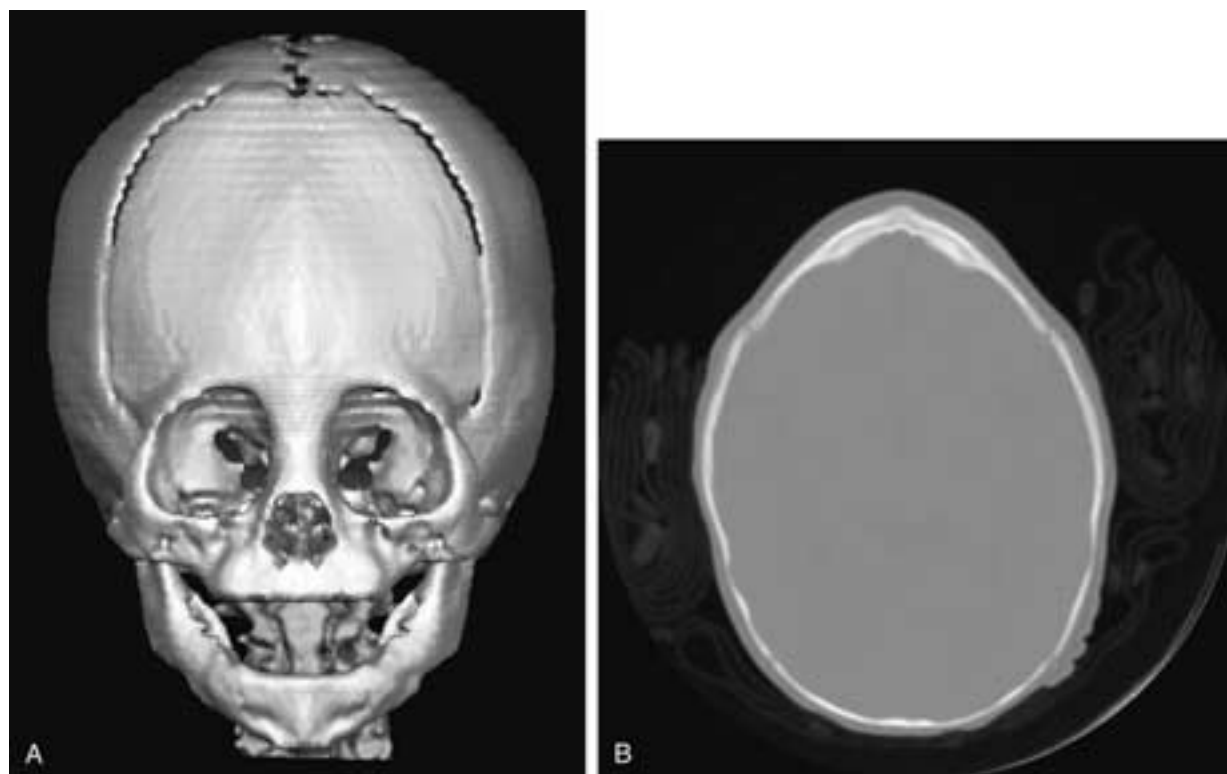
Trigonocephaly in a 3-month-old girl. A, Three-dimensional CT of the facial skeleton. B, Axial bone CT through the metopic suture. Premature closure of the metopic suture leads to hypotelorism, upward medial pointing of the orbital contours (“quizzical orbits”) and a keel-shaped brow.
